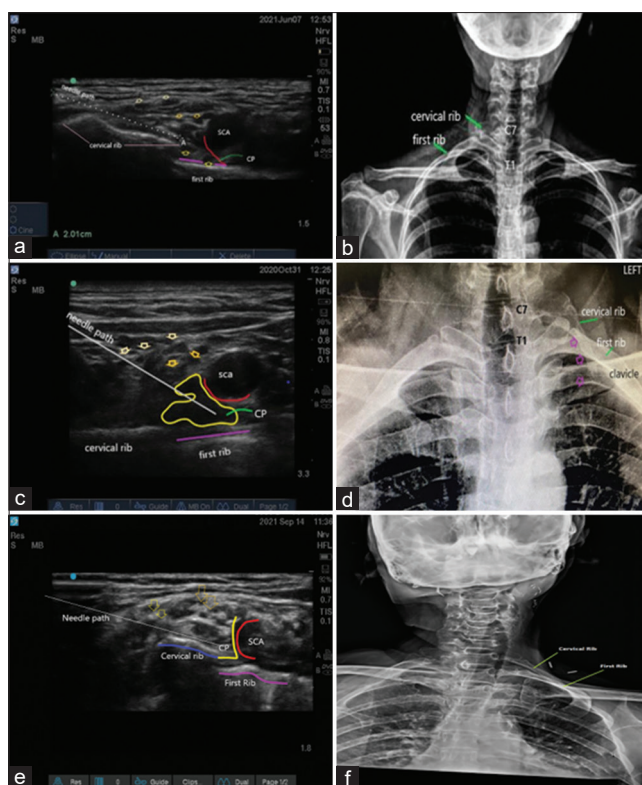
(a): Ultrasound image showing the right supraclavicular scan with the orientation marker laterally. The dotted line shows the proposed needle trajectory for a supraclavicular block. SCA = Subclavian artery; CP = Corner pocket; Yellow arrows = depict brachial plexus elements; A-Needle path (b): Neck X-ray depicting the non-ossified cervical rib on the right side. (c): Ultrasound image of the left supraclavicular fossa with orientation marker laterally. CP = Corner pocket; sca = Subclavian artery; Yellow arrows = Upper and middle trunks and divisions of brachial plexus. (d): X-ray depicting left-sided cervical rib. (e): Ultrasound image of the left supraclavicular area with orientation marker laterally. CP = Corner pocket; SCA = Subclavian artery; Yellow arrows = Upper and middle trunks and divisions of the brachial plexus. (f): X-ray depicting left-sided cervical rib
